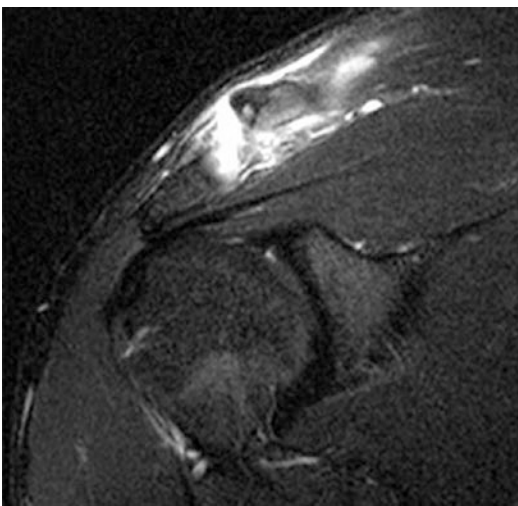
MRI of a right shoulder (coronal view) showing OA of AC joint with effusion, bone edema, and cysts
